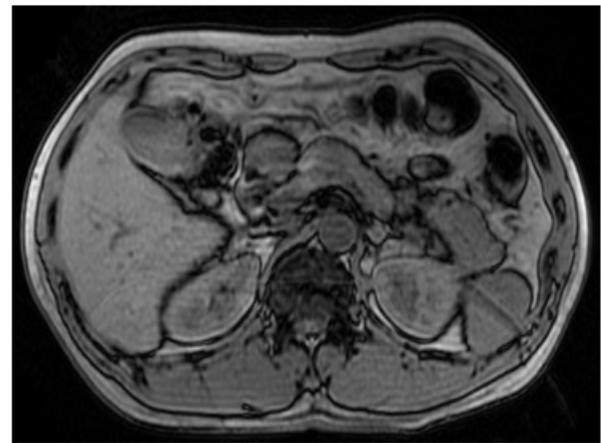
MRI shows nodular abnormal signal shadow in the pancreatic body(1.6x1.6cm)
